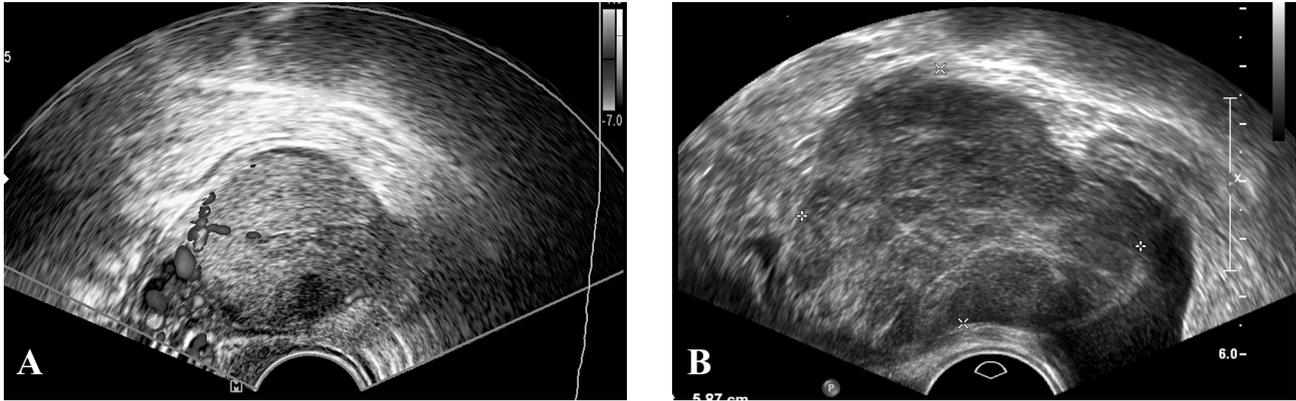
Ultrasound images (A) taken three months prior to the operation showing 4.07×3.42 cm mixed echogenic mass lesion with hypervascularity surrounding the mass, (B) taken a week before the operation showing inhomogenous mass lesion.
